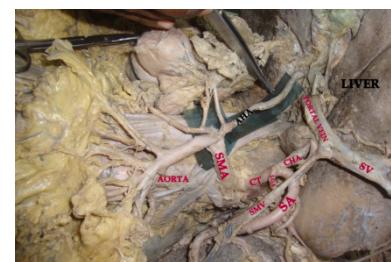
showing origin of right aberrant hepatic artery from superior mesenteric artery. CHA- Common hepatic artery, SMA- Superior mesenteric artery, AHA- Aberrant hepatic artery, CT- Coeliac trunk, SA- Splenic artery, LGA- Left gastric artery, SV- Splenic vein, SMV- Superior mesenteric vein
